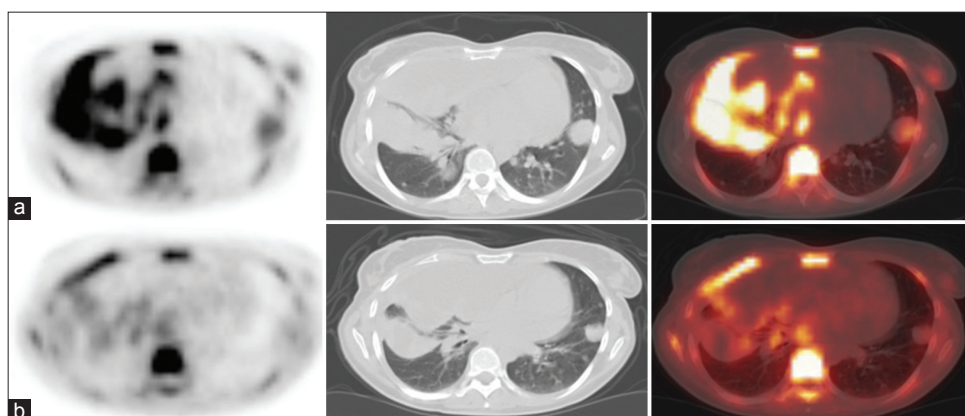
F-18 FLT PET/CT scan. Transaxial images: (a) Before treatment and (b) after treatment. A female patient with pleural metastases of a melanoma, showing decreased FLT uptake in the pleural metastases after treatment with Selumetinib for 2 weeks (Patient No. 1) [Table 1]
